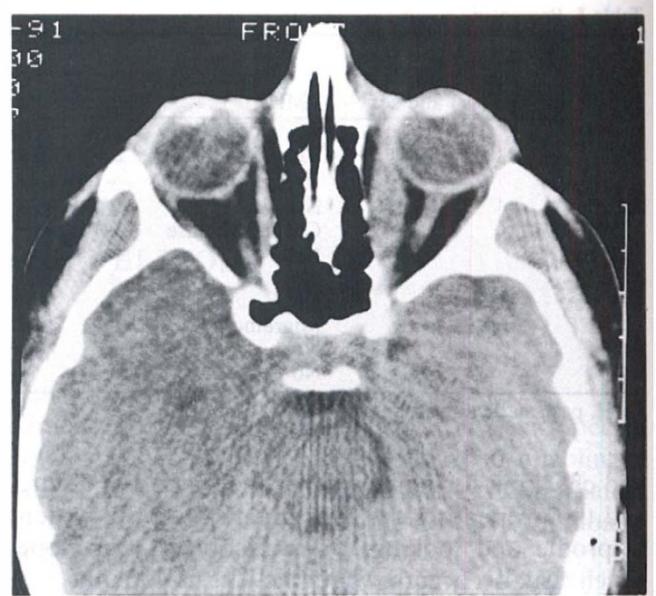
Patient 1. CT scan of the orbits showing marked enlargement of the left medial rectus from the insertion to the orbital apex.
